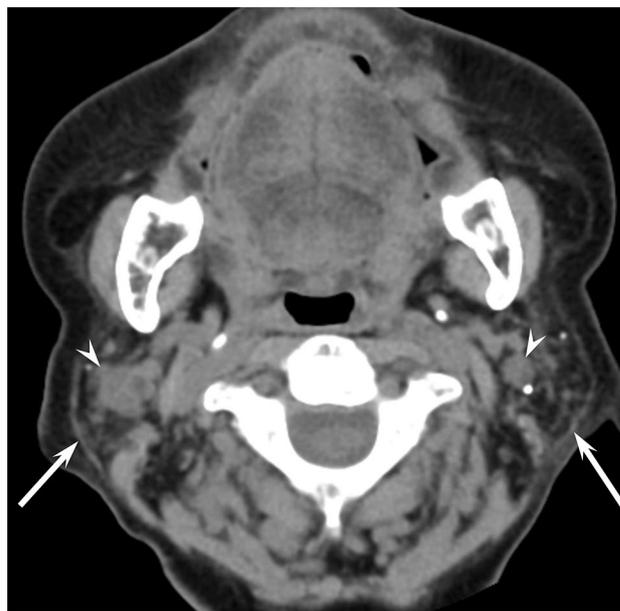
A 73-year-old woman with benign lymphoepithelial lesion of Sjögren's syndrome. Unenhanced CT image shows combined solid and cystic lesions (arrow heads) within the bilateral atrophied parotid glands (arrows)
